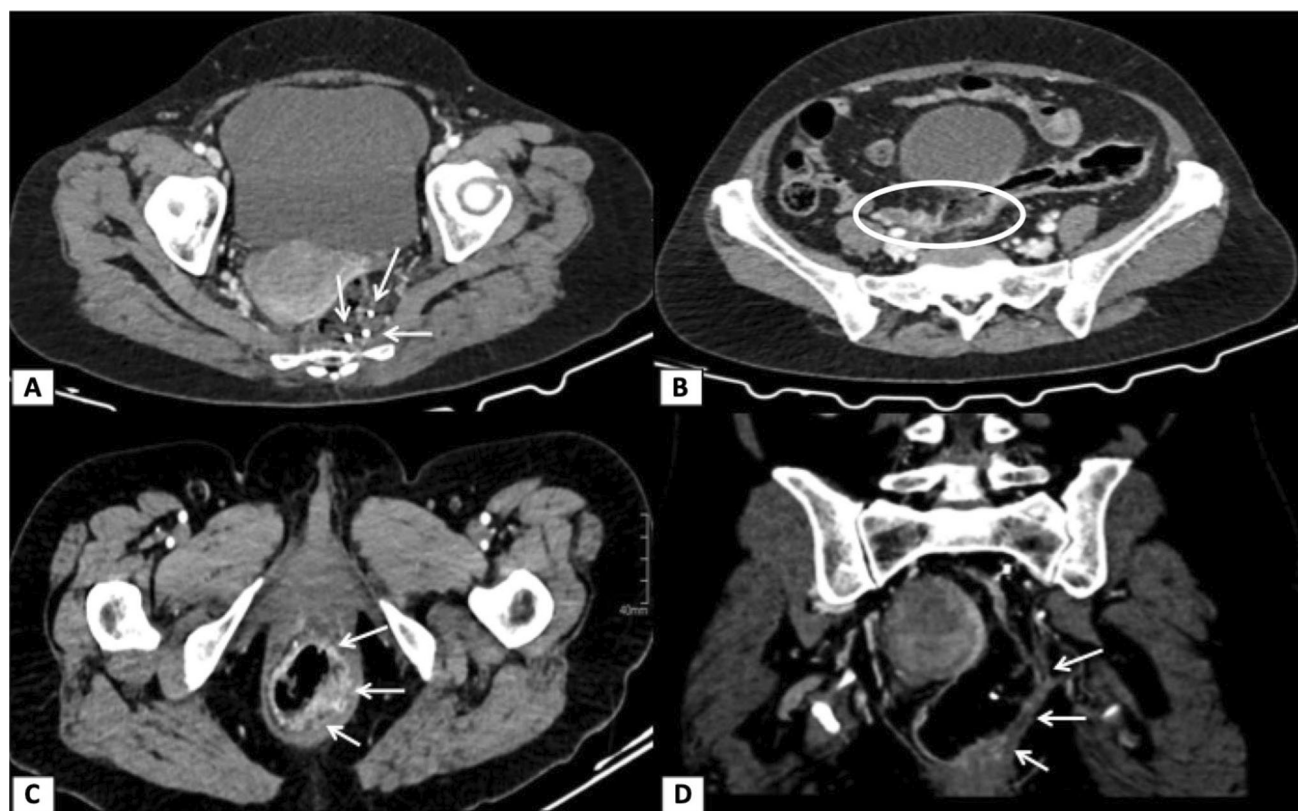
CT scan two weeks after embolization. A: Metallic microcoils in rectum (arrows). B: Thinning of the rectal wall until the rectosigmoid transition (circle). C: Submucosal edema and slightly
